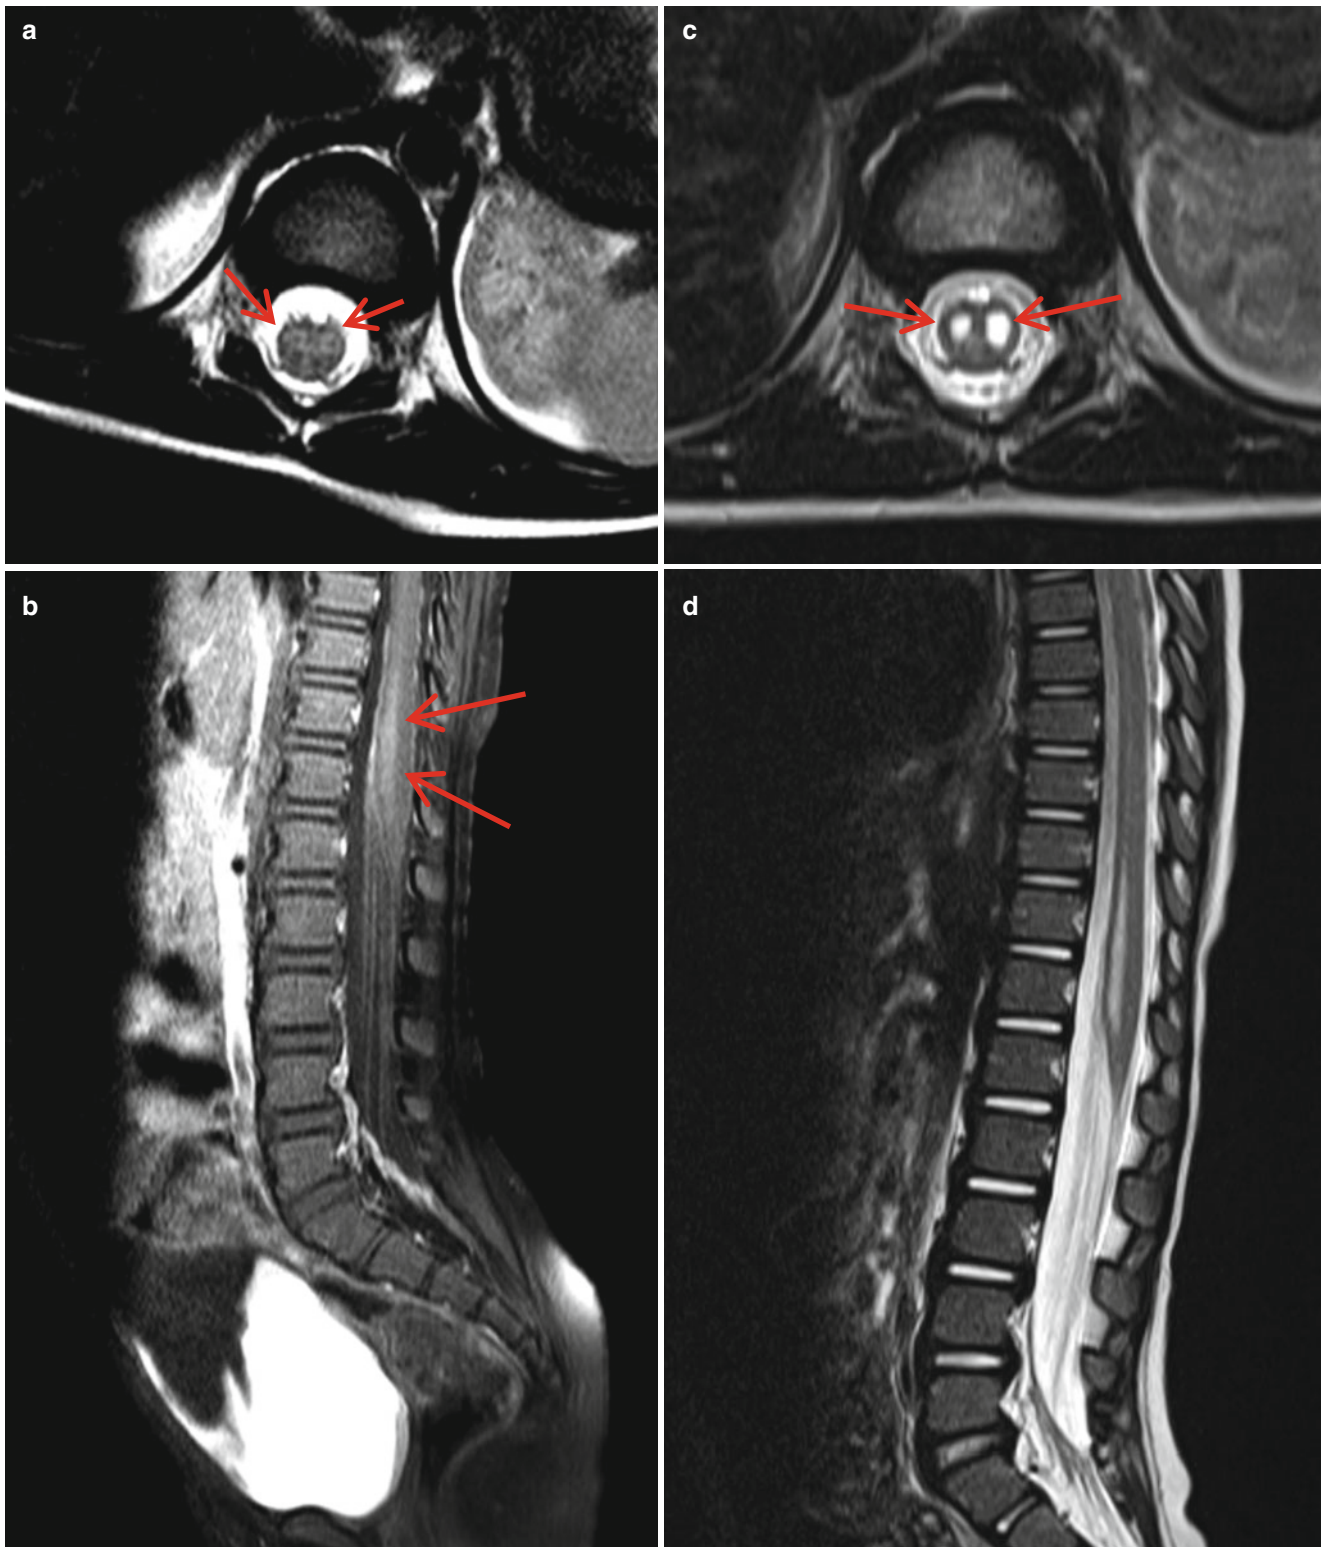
Anterior horn cell involvement in transverse myelitis due to enterovirus. (a) T2-weighted image of the lumbar spine shows subtle increased signals (*arrows*) in the anterior aspect of the spinal cord. (b) Postcontrast image shows well-defined homogenous enhancement
